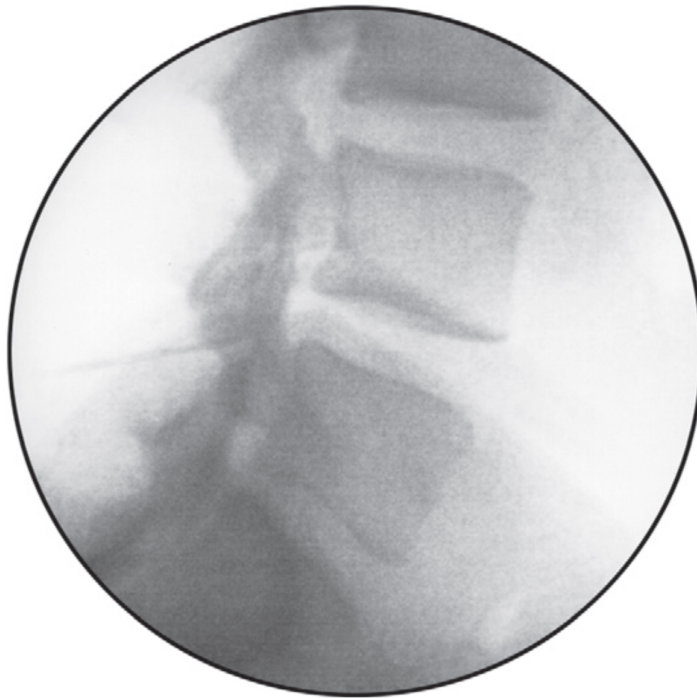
B : Lateral radiograph of lumbar epidurogram.
